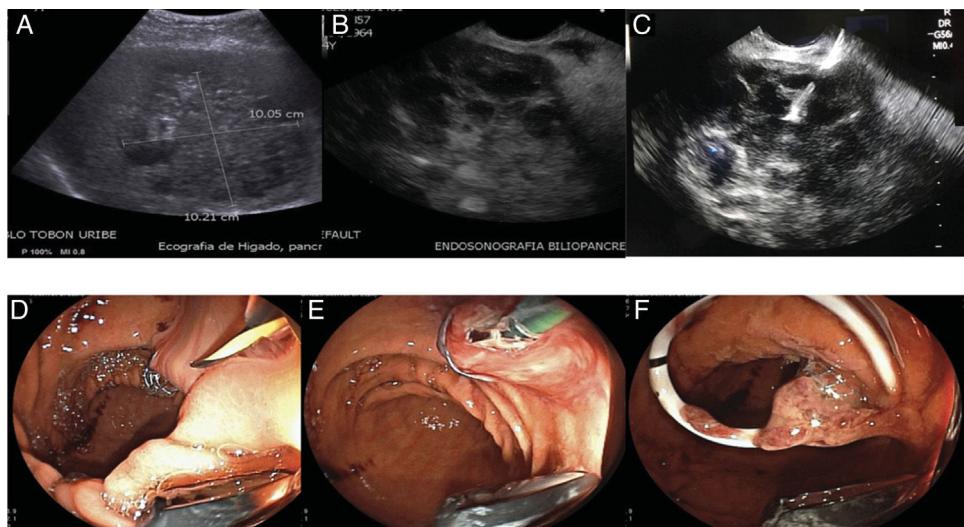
A) Hepatobiliary ultrasound identifying a liver abscess larger than 10 cm. B) Linear view of the liver abscess, through endoscopic ultrasound. C) Transgastric puncture of the abscess, D) passage of the covered metallic stent, in which drainage of abundant thick purulent material can be seen. E) Dilatation of the proximal end of the stent, F) passage of the coaxial double-pigtail catheter into the metallic stent.
